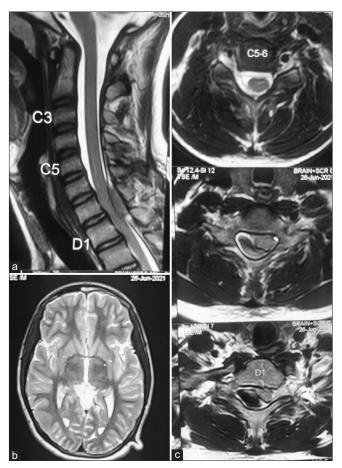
(a and c) There was a extradural lesion at C7-D1 level which was iso/hyperintense to cord on T1-weighed images and hyperintense with hypointense band on T2 images (b) MRI (magnetic resonance imaging) brain was suggestive of normal study, with no features of stroke or intracranial bleed.
